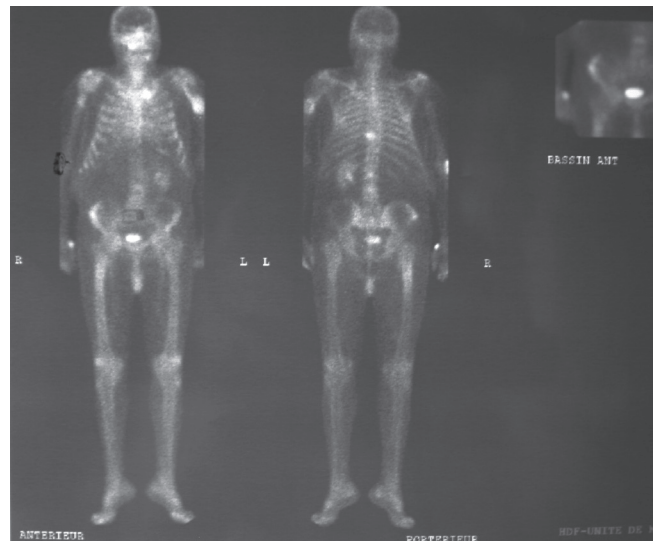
Bone scintigraphy after iv injection of 19 mCi of HMDP-Tc.
